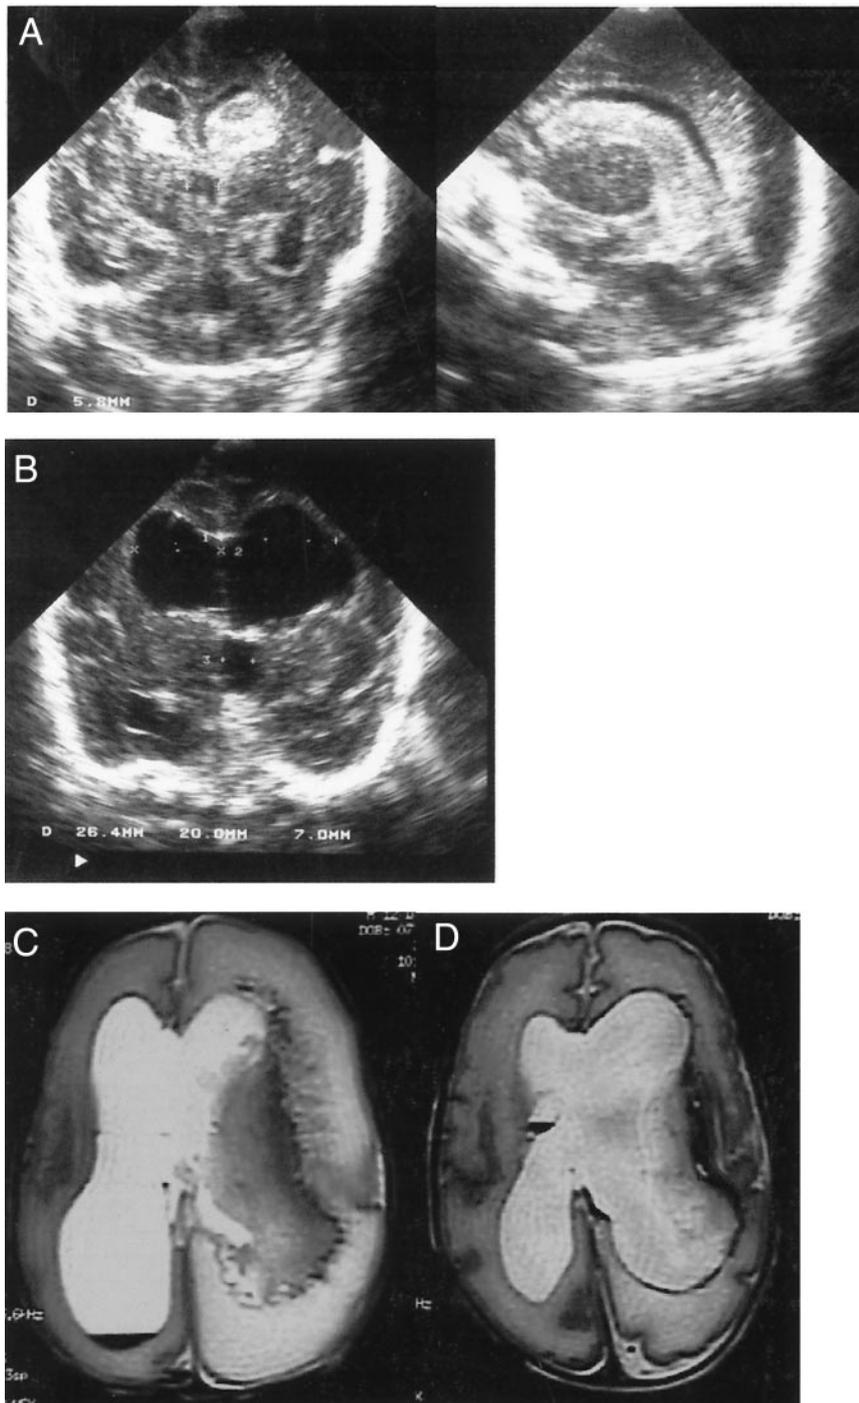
Cerebral ultrasound scans showing extensive intraventricular clot (white) before administration of TPA (midcoronal and parasagittal views; a), measurement of width of the lateral ventricles and third ventricle (coronal; b). Cerebral magnetic resonance images (T2 weighted): c, IVH (dark) and with ventricular dilation (white). There is considerable edema (white) in the parenchyma of the left hemisphere. d, Clearing of intraventricular blood after DRIFT and reduction in edema in the left hemisphere.
